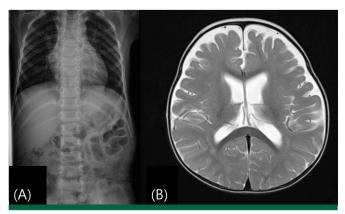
X-ray and brain magnetic resonance imaging (MRI) finding for Patient 1. (A) No skeletal abnormalities of chest cavity and spine. (B) Normal T2 weighted axial MRI at 11 months of age.
